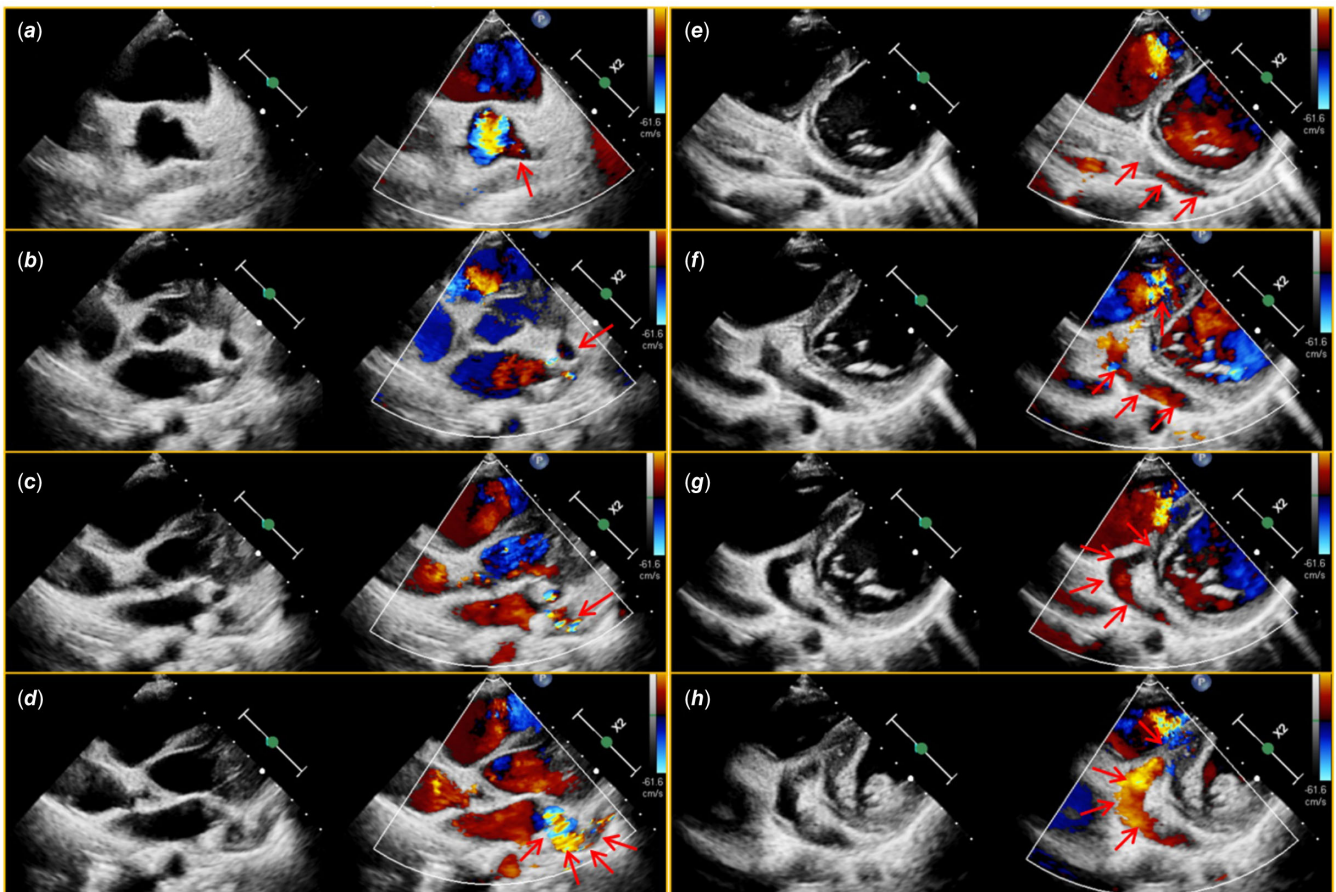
a-h.* The parasternal short axis sweeps from the base to the mid-ventricular segment tracing the hugely dilated left main (arrow in A) and left circumflex artery (arrows) in the atrioventricular groove, ultimately draining to the right ventricle via an inter-ventricular septum.
